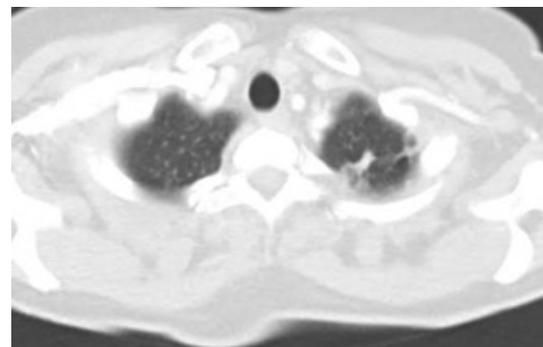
Thoracic CT: calcified micronodule and fibrotic tracts in the left upper lobe.
